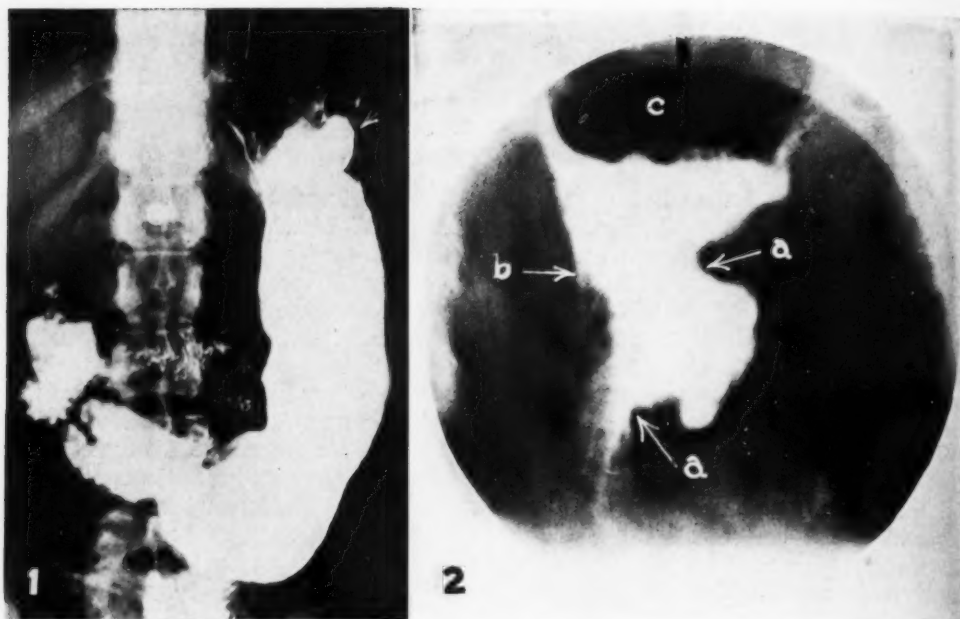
Roentgenogram (Jan. 22, 1946) showing large niche on greater curvature at the junction of the fundus and pars media.
